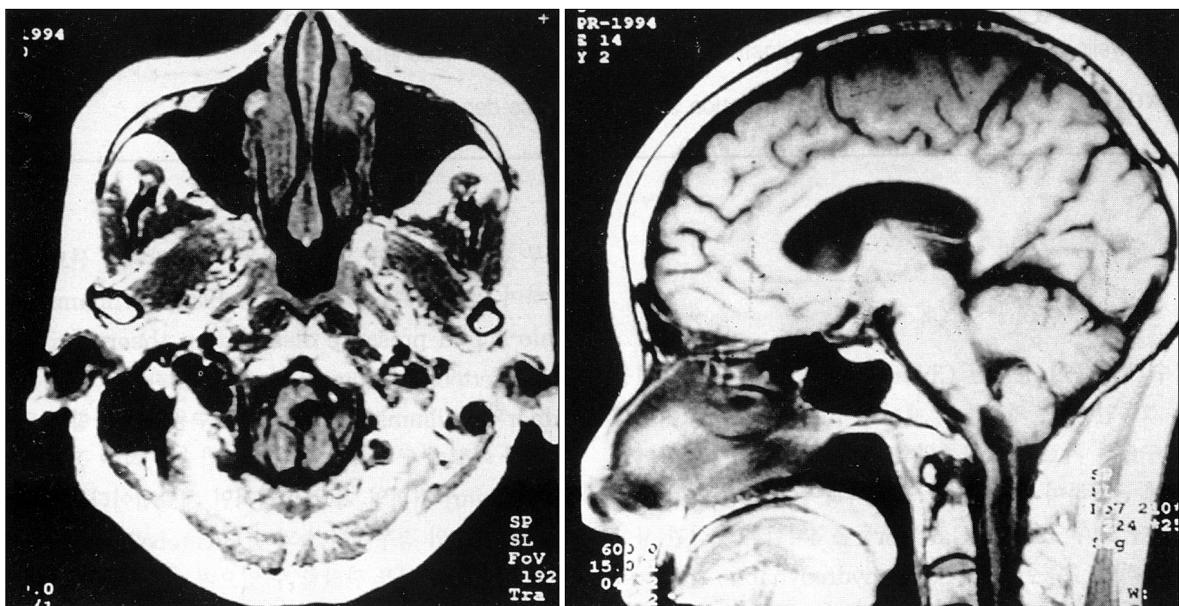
Preoperative magnetic resonance imaging(T1W1 : axial/sagittal) shows syringomyelia and syringobulbia with chiari malformation type I.
